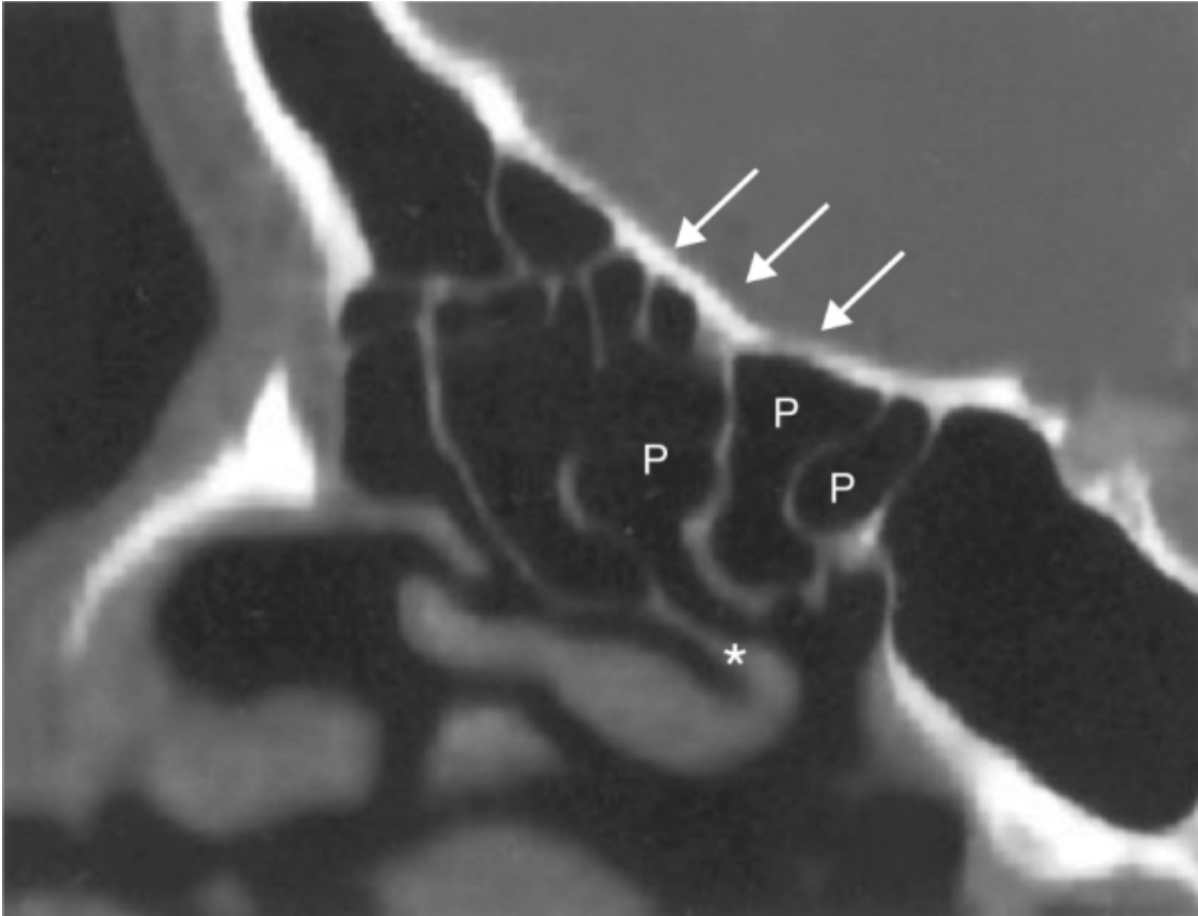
In this sagittal computed tomography section, the sloping of the skull base posteriorly is evident (*arrows*). The posterior ethmoid cells and recesses drain above the middle turbinate and are identified with a *P*. The basal lamella of the middle turbinate is marked with an *asterisk*.
